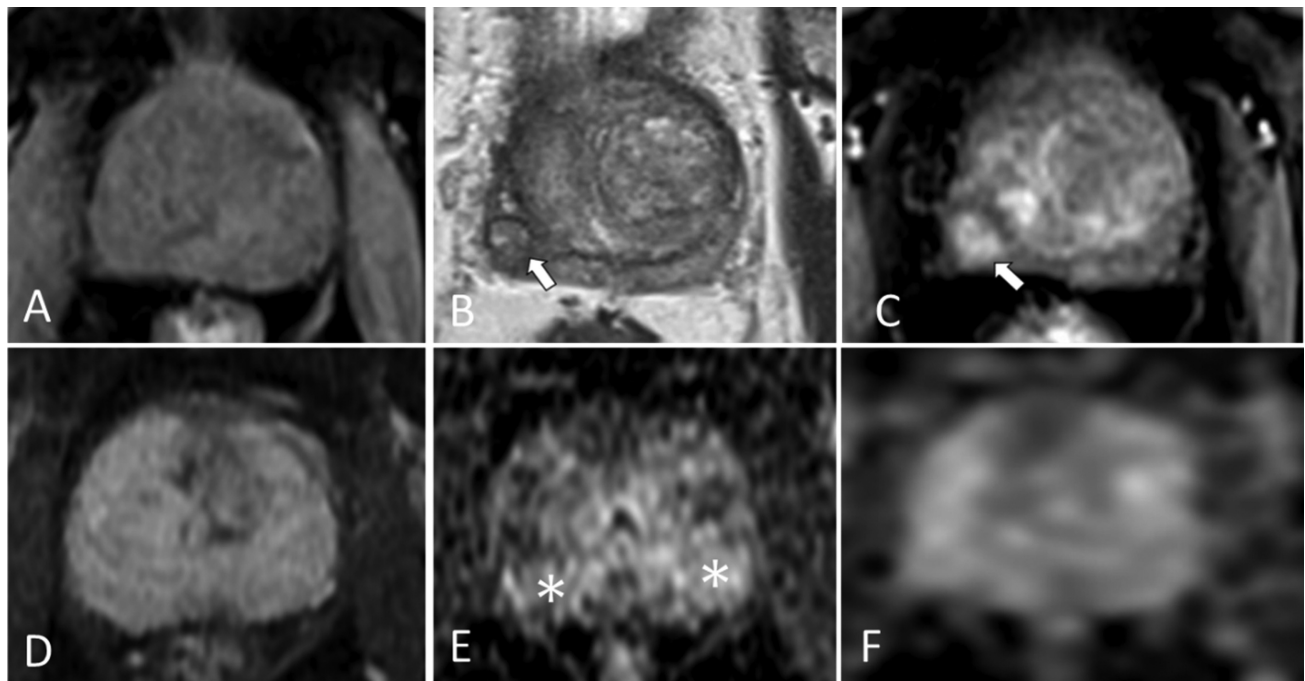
Dynamic contrast-enhanced (DCE) negative categories. Absent early enhancement (A – DCE T1 axial), early enhancement in the extruded nodule (arrows) (B – T2 axial, C – diffusion-weighted imaging [DWI] axial), widespread enhancement (D – DCE T1 axial), enhancement without corresponding restricted diffusion (E – apparent diffusion coefficient [ADC] axial, F – DWI axial).
